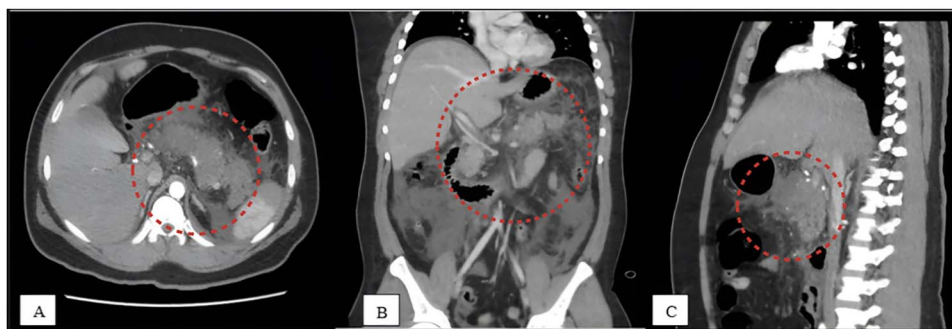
CT abdomen with intravenous contrast ((A) axial view, (B) coronal view and (C) sagittal view) shows a swollen pancreas with significant peripancreatic fat stranding extending to the root of the mesentery and a non-enhancing body of the pancreas representing 30–40% necrosis—features suggestive of acute severe pancreatitis (dotted red circle).
